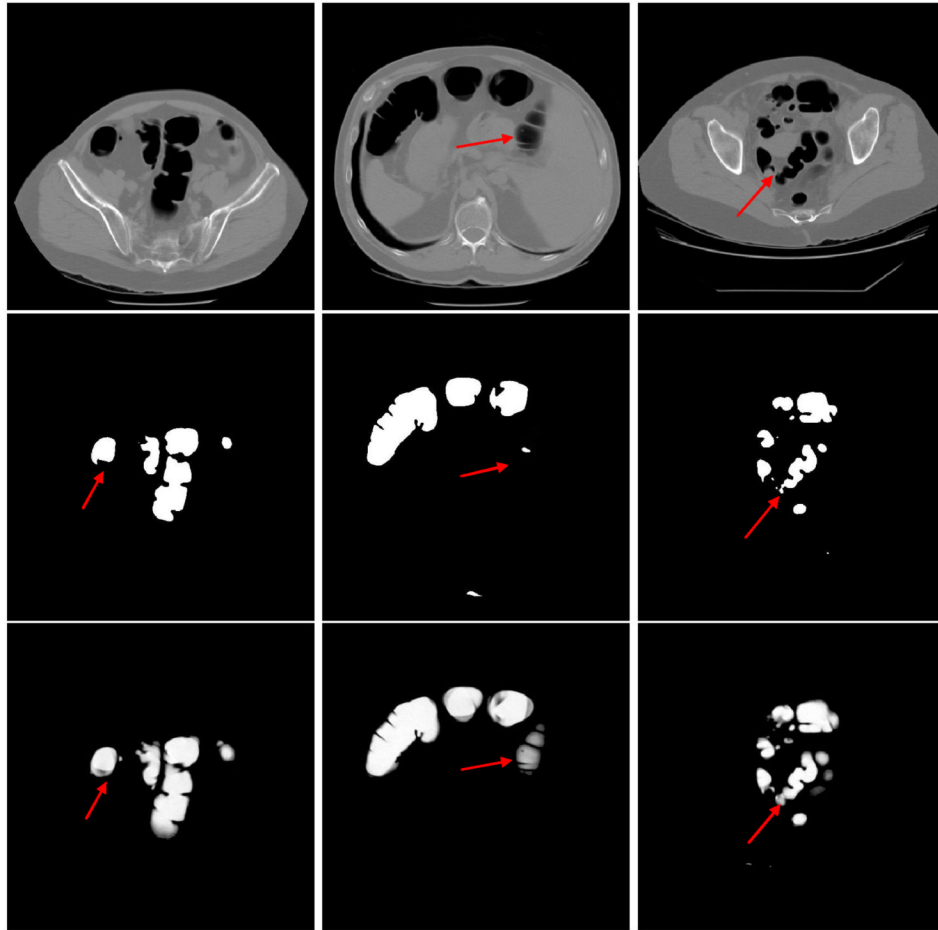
Comparison of two different image segmentation methods. The pictures in the top row are the original CT image slices. The middle row shows the results of our previous hard segmentation algorithm. The results of our current PV segmentation method are shown in the bottom row. The PV image segmentation preserves more details because of its consideration of the PV effect than the hard image segmentation which does not consider the PV effect. The arrows indicate some example locations where the PV segmentation preserves more details.
